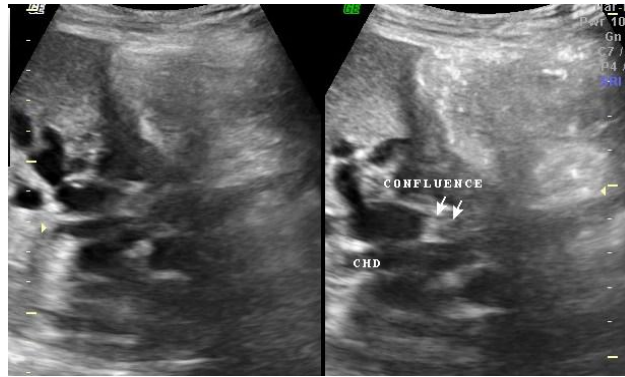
a,b. Ultrasound image showing echogenic soft tissue mass lesion within the CHD and proximal CBD (double arrow) with upstream dilatation of CHD & IHBR
